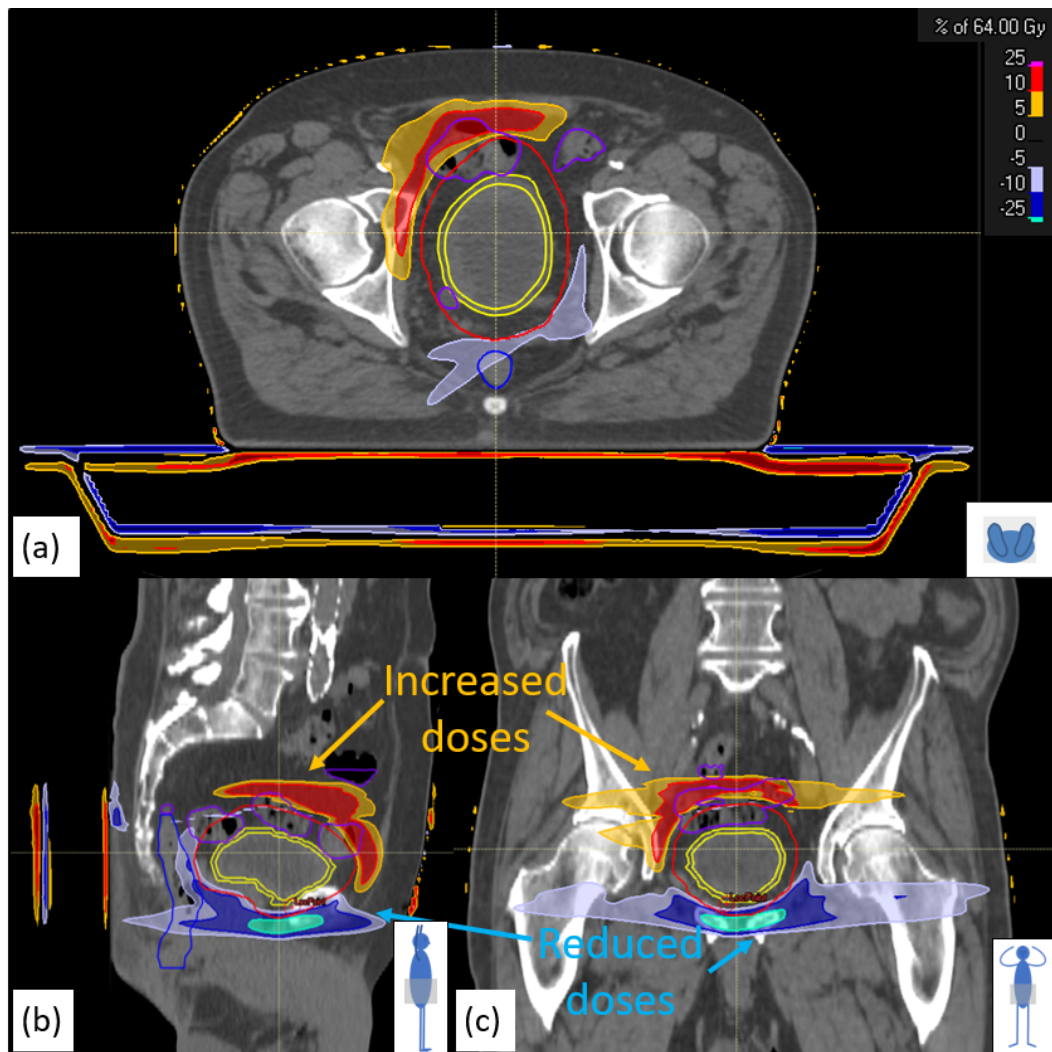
Differences between original planned dose distribution and the dose distributions which would have been delivered using the standard 64 Gy plan, based on re-calculation on a CBCT image acquired immediately prior to treatment which are then mapped back onto the original planning CT using the DR. Differences shown for (a) transaxial, (b) sagittal and (c) coronal views of the patient.
